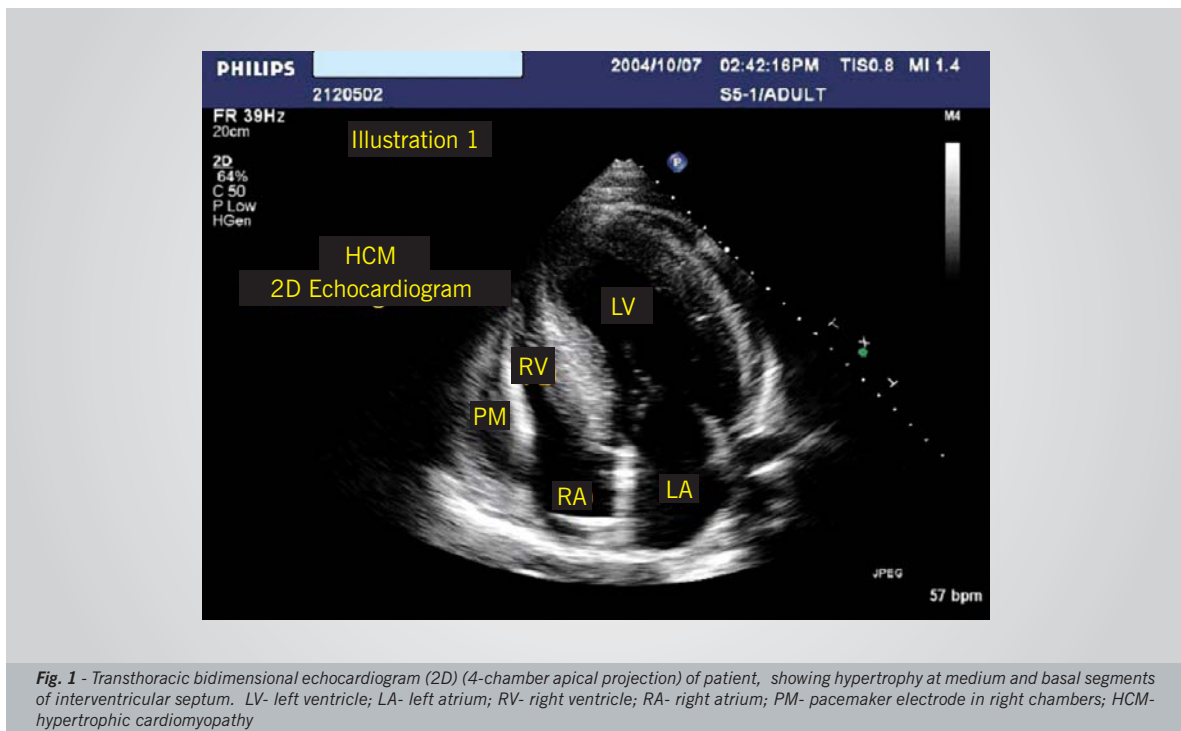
Transthoracic bidimensional echocardiogram (2D) (4-chamber apical projection) of patient, showing hypertrophy at medium and basal segments of interventricular septum. LV- left ventricle; LA- left atrium; RV- right ventricle; RA- right atrium; PM- pacemaker electrode in right chambers; HCM- hypertrophic cardiomyopathy
